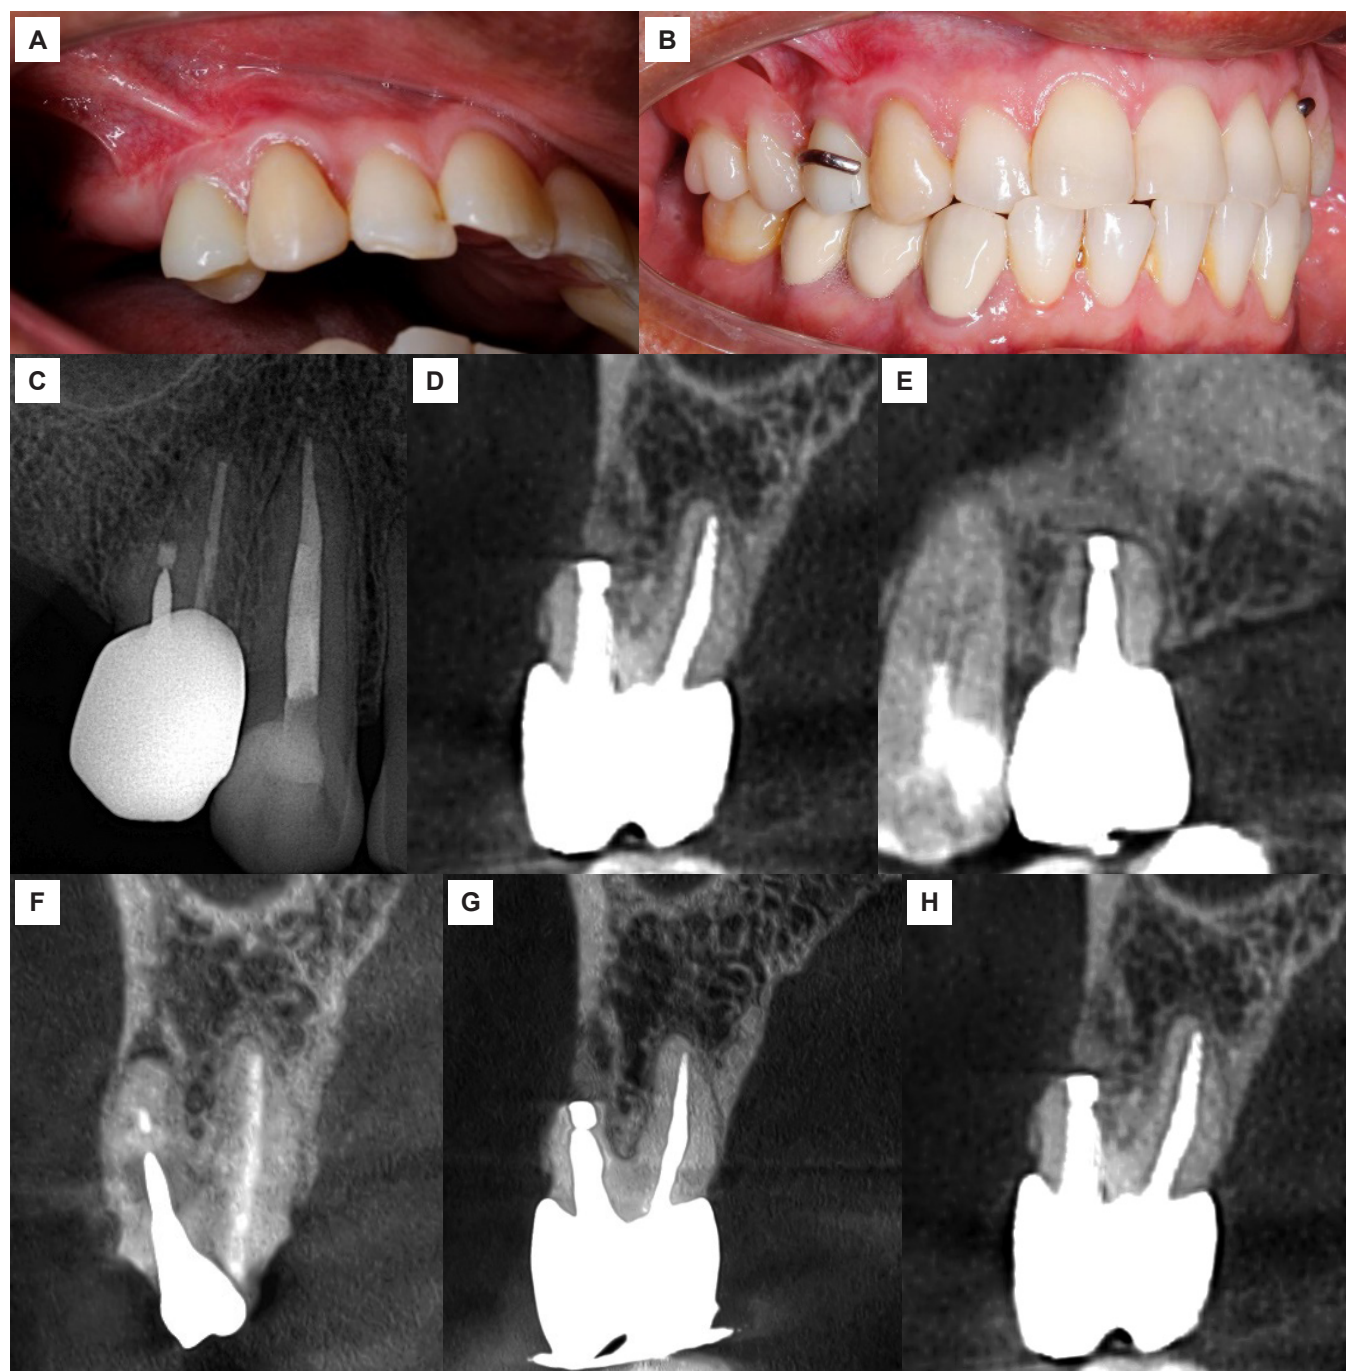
(A) Definitive rehabilitation with a zirconia crown. (B) Rehabilitation with a provisional removable partial denture. (C) Twelve-month follow-up periapical radiograph. (D) Twelve-month follow-up CBCT scan (coronal section). (E) Twelve-month follow-up CBCT scan (sagittal section). (F) Initial CBCT coronal section. (G) Seven-month follow-up CBCT scan (coronal section). (H) Twelve-month follow-up CBCT scan (coronal section).
